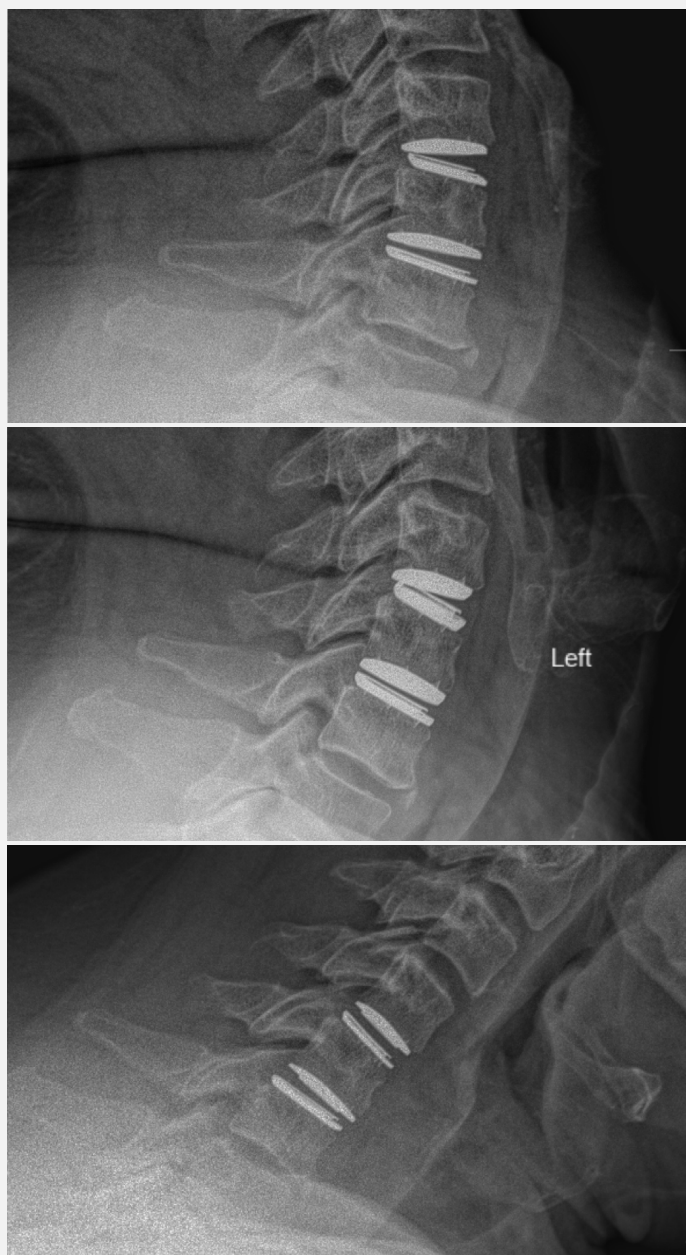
3 months post-operative x-rays
